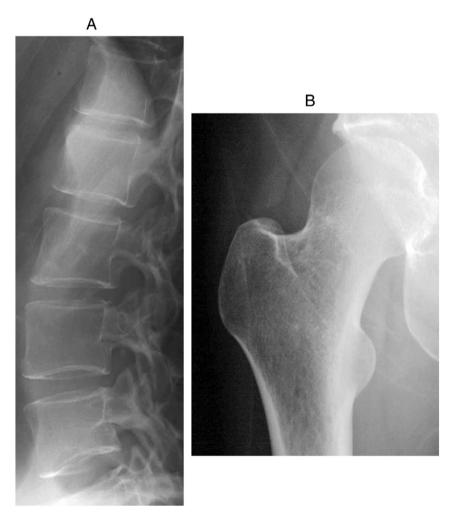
Lateral radiograph of the lumbar vertebrae (A) and the right femoral neck (B) shows reduced bone density, cortical thinning and a reduced number of trabeculae.
